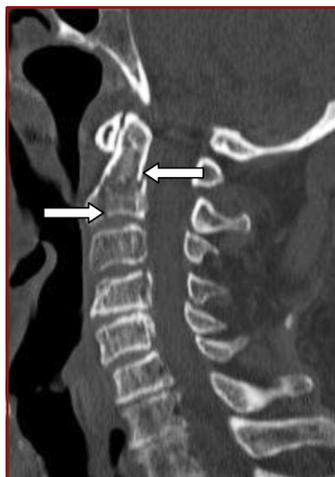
Sagittal computed tomography of a complex C2 body fracture. Note the multiple fractures within the corpus of the axis.
